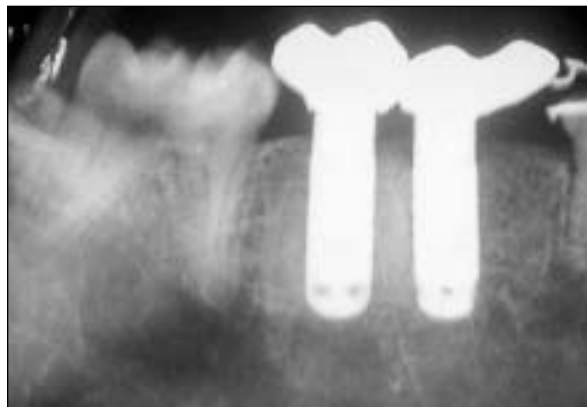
Radiograph taken at 3 months, following prosthesis placement.
